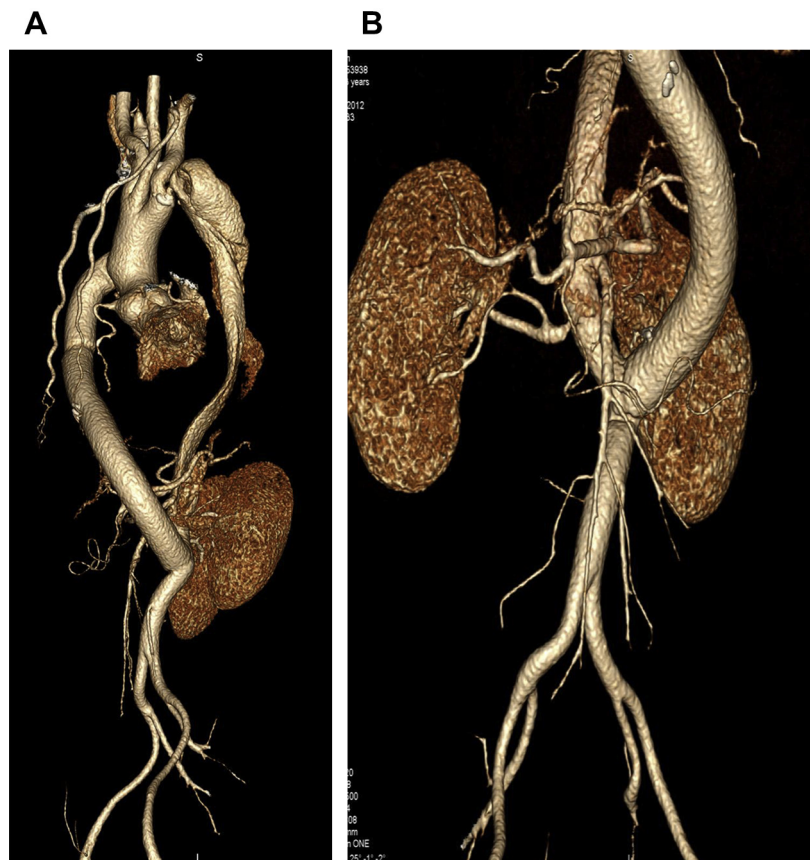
A, Three-dimensional computed tomography angiography with volume rendering showed the extra-anatomic bypass, the native aorta with the congenital coarctation, and a dilated dissected artery. B, The perfusion of the visceral arteries was good.
